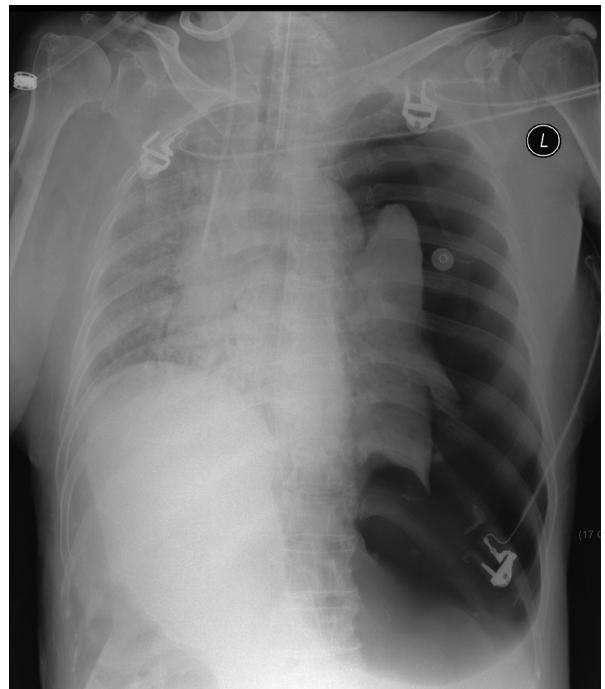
Chest radiograph after BAL showed evident left pneumothorax.
